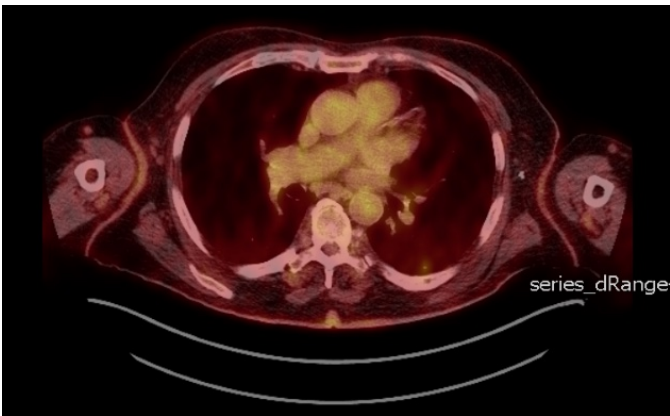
Left lower lobe hypermetabolic lung nodules with focal intense FDG uptake on PET-CT completed in January 2021.
